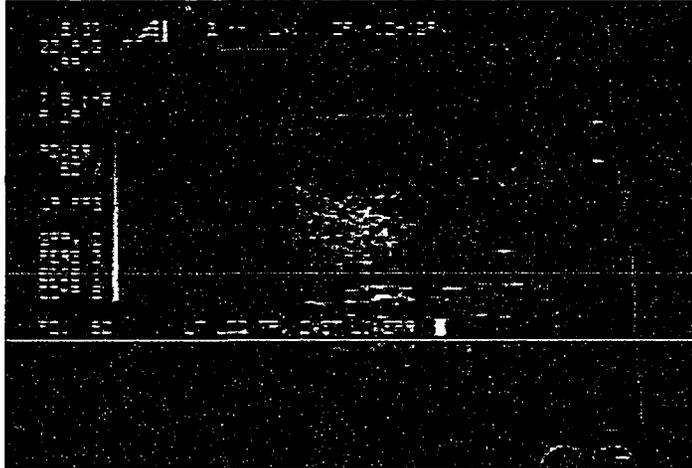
Ultrasound image of breast tumor.
